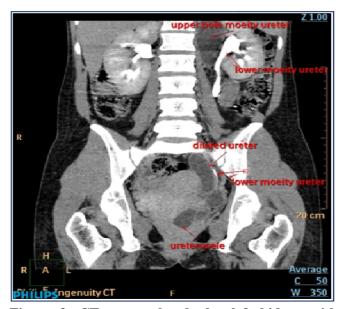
CT urography duplex left kidney with ureterocele in upper moiety ureter
